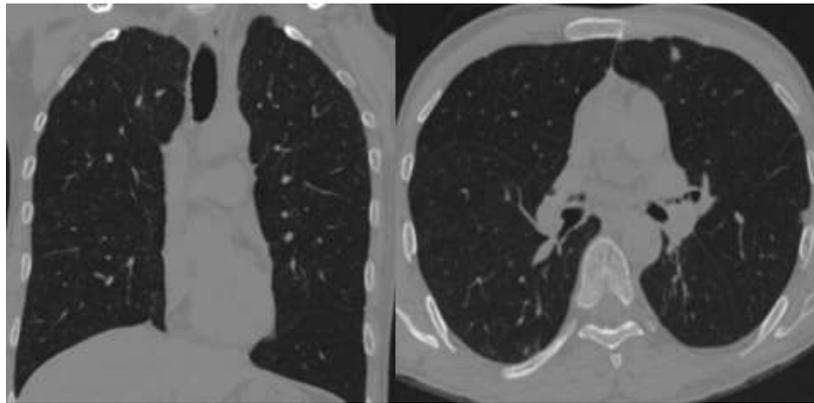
A & B: HRCT thorax showed emphysematous changes in AF patients
